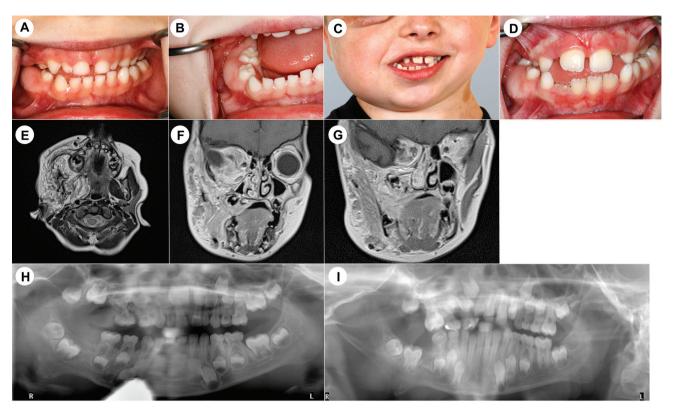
Clinical findings (A-D), magnetic resonance images (E-G) and orthopantomograms (H-I) of a patient with right-sided plexiform neurofibroma (PNF) and maxillary microdont. (A) Photographs of oral inspection of the 6-year-old patient (A, B) reveal deciduous dentition, tumorous bulging of alveolar process due to oral PNF, and no emergence of mandibular right first permanent molar (B). Photographs en face [(C), cropped image] and oral view (D) reveal an extensive soft facial tissue tumor and physiological functioning of perioral muscles, vestibular bulging of right mandibular alveolar process and delayed emergence of mandibular right second incisor (C and D: 8-year-old patient). Magnetic resonance images show (E) the extension of the facial PNF of the right half of the face and skull base using the example of the plane showing the maxillary molars (axial plane). (F) Figure shows cranio-caudal extension of the tumor from the right skull base to the lower margin of the mandible. The half-sided delimitation of the tumorous lesions is also clearly visible in this plane. On the right side, the maxillary right first molar is completely encased by tumorous tissue in the crown area. The apical dimension of the tooth borders cranially on a thin layer of bone. A few sections further dorsal, the placement of the second right upper molar is shown (F and G: coronal plane; E-G: 7-year-old patient). (H) Orthopantomogram of the 6-year-old boy shows complete deciduous dentition and germs of all four first and second permanent molars. (I) Three years and two months later, the three first molars emerged into the oral cavity and gained occlusal contact. The root of the mandibular right first molar is developed (visible bifurcation of roots). However, root development is far behind compared to the mandibular left first molar. Positions and developmental stage of second molars did not change substantially during the observation period (H and I).
